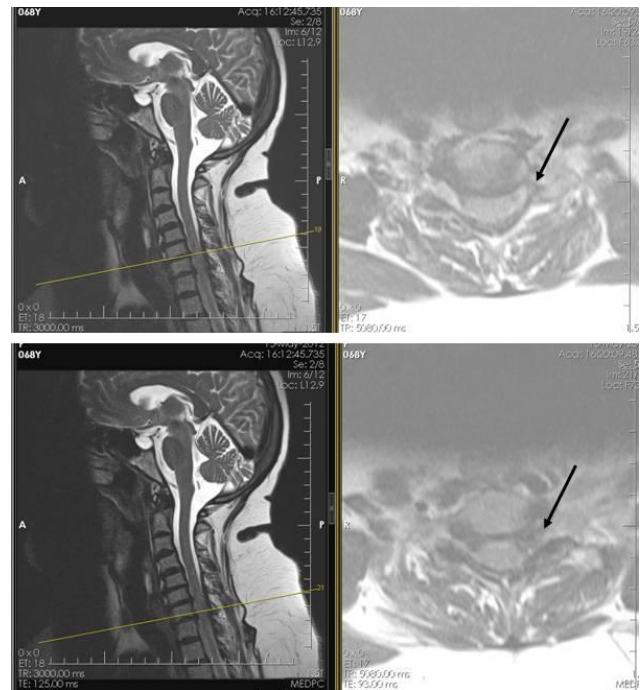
T2-weighted sagittal and axial cervical MRI sections show cervical disc herniation on the left side. The upper image shows C6-7 and the lower image shows C7-T1.
